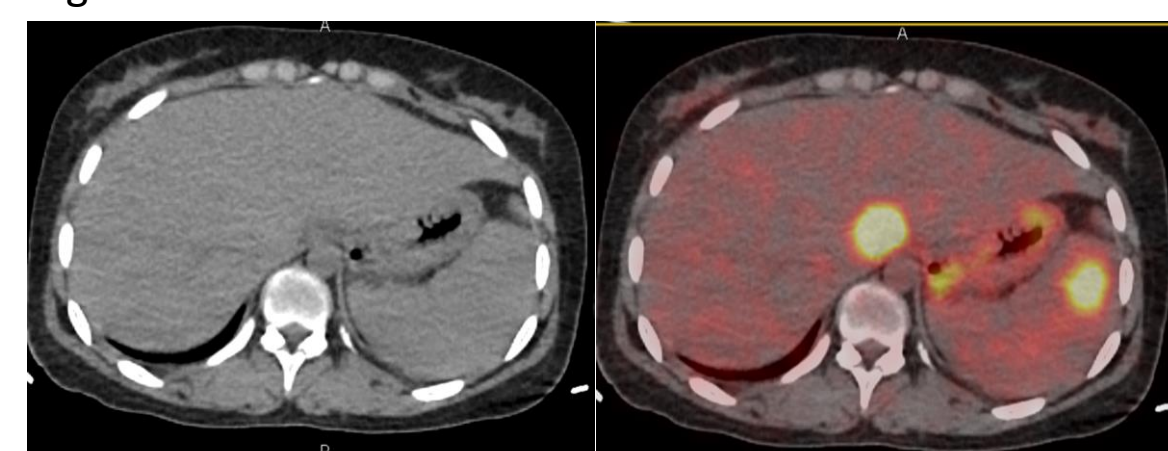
Metabolically active lesions identified in the liver and spleen, not seen in CT, resulting in upgrade of stage
